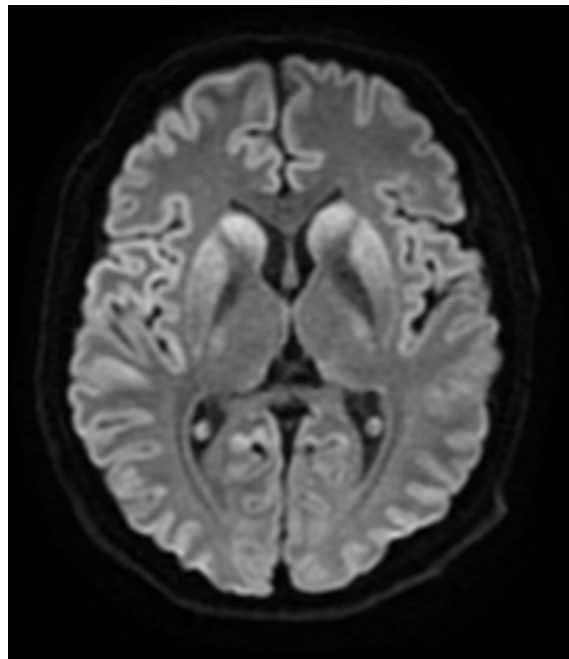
MRI brain without contrast obtained on admission. Axial slice on DWI sequence demonstrates bilateral hyperintensities of the caudate and striatal nuclei along with insular cortical ribboning.
